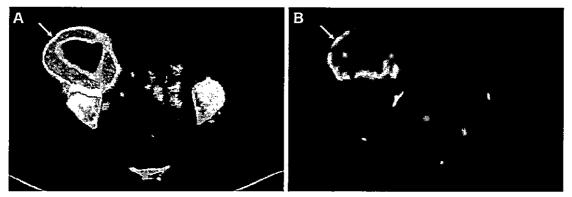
Malignant peripheral nerve sheath tumor involving the right inguinal region in a 48-year-old woman with NF1 who presented with worsening right inguinal pain. (A) Axial fluorodeoxyglucose (FDG) PET/CT image shows a large mass in the right inguinal region with FDG avidity (arrow). (B) Axial diffusion-weighted image shows the mass with reduced diffusivity, predominantly along the periphery of the mass (arrow). (Apparent diffusion coefficient [ADC] map not shown.)
